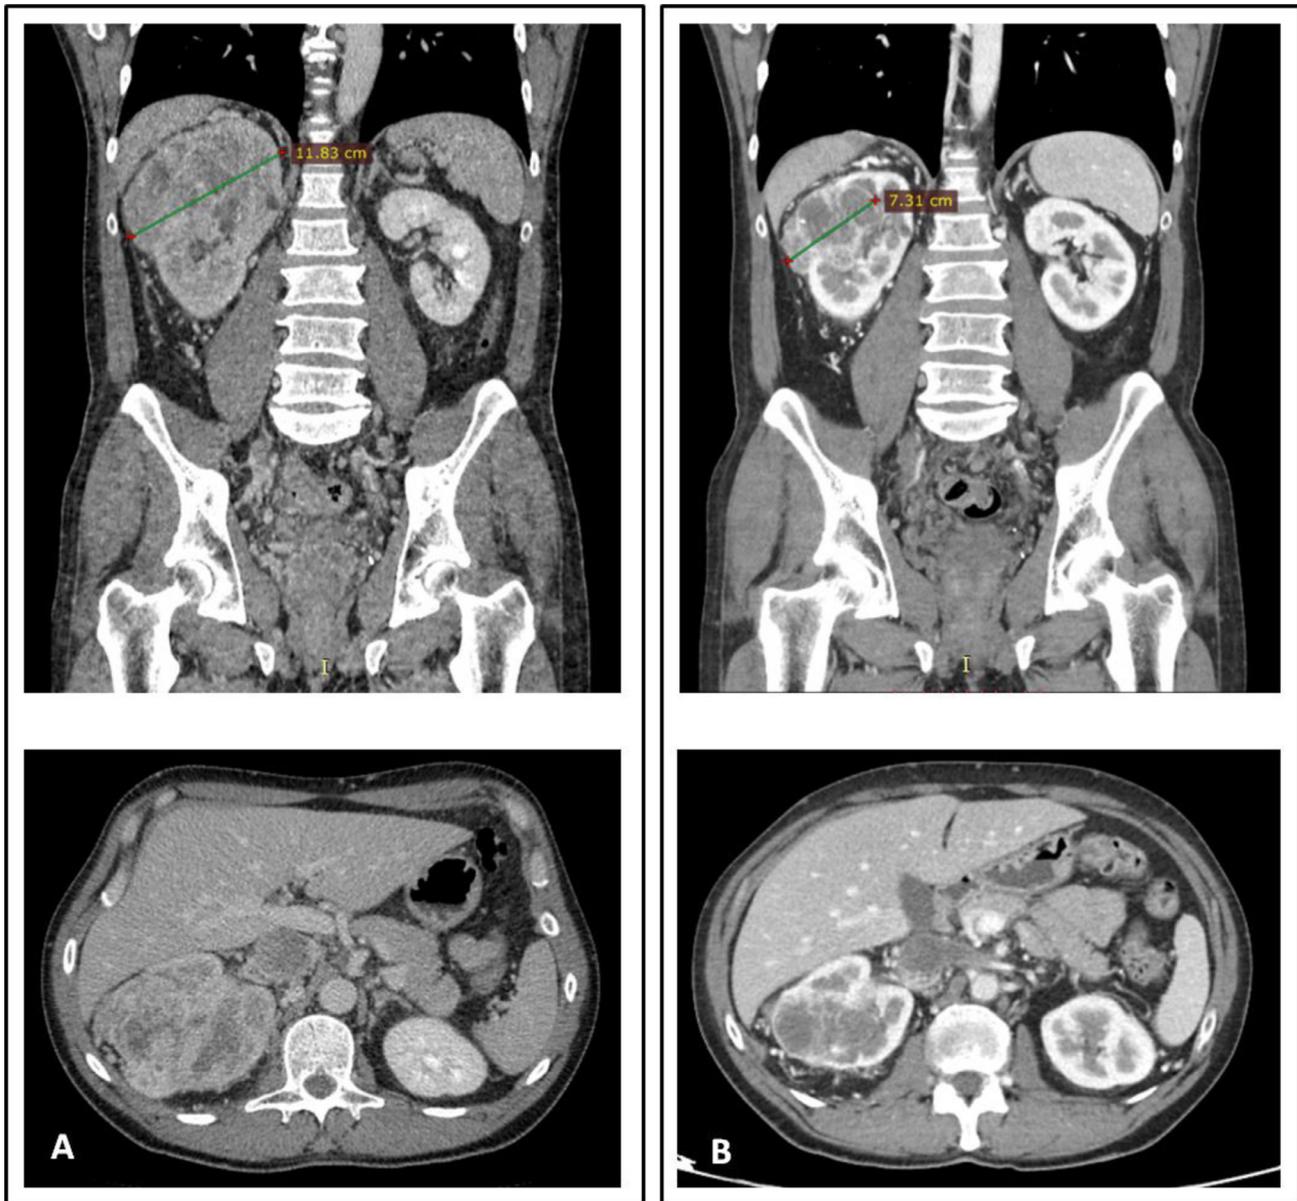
CT scan showing that primary renal tumor (A) significantly reduces its size after treatment with bevacizumab for 8 weeks (B). CT = computed tomography.
